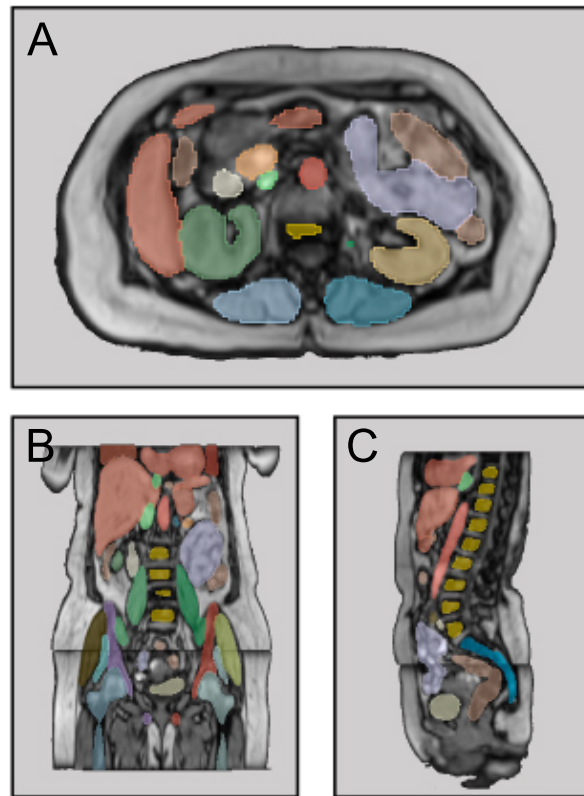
Sample segmentation of MRSegmentator for axial (A), coronal (B) and sagittal (C) views of an MRI image.
